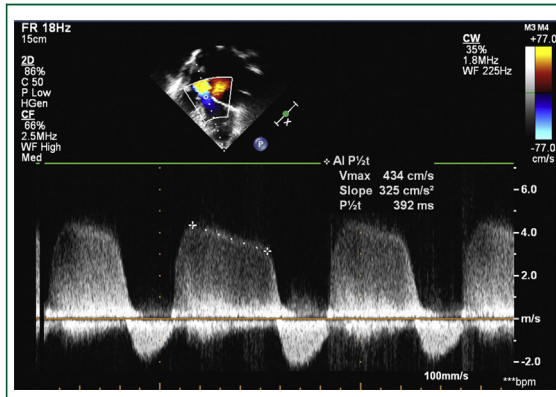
Pressure half-time of aortic regurgitant Doppler jet suggestive of moderate aortic regurgitation.
